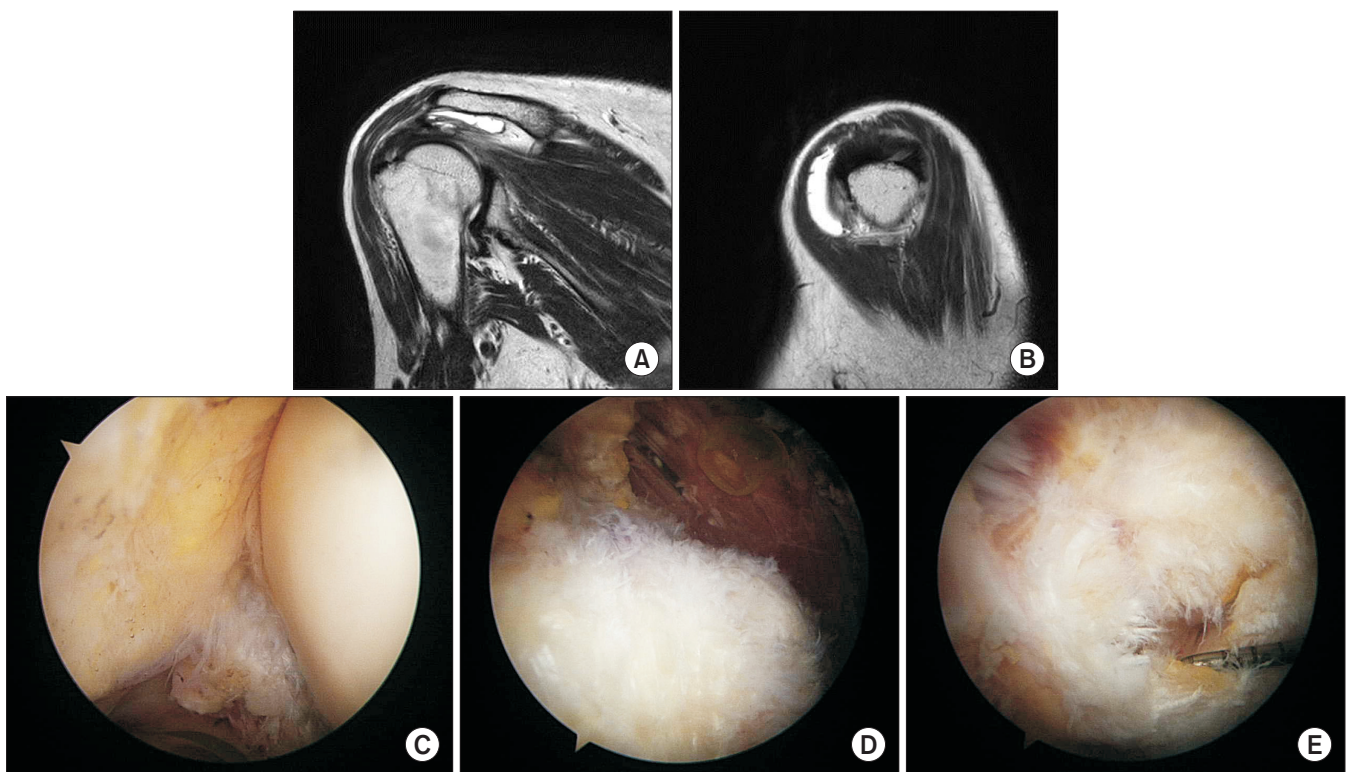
(A, B) Preoperative magnetic resonance imaging of a 70-year-old female patient (ID-1) suggests concealed interstitial delamination at the anterior infrapinatus tendon. The intraoperative, arthroscopic findings revealed an articular-sided partial tear of the supraspinatus tendon (C, D) and a full thickness tear of the infrapinatus tendon (E).
